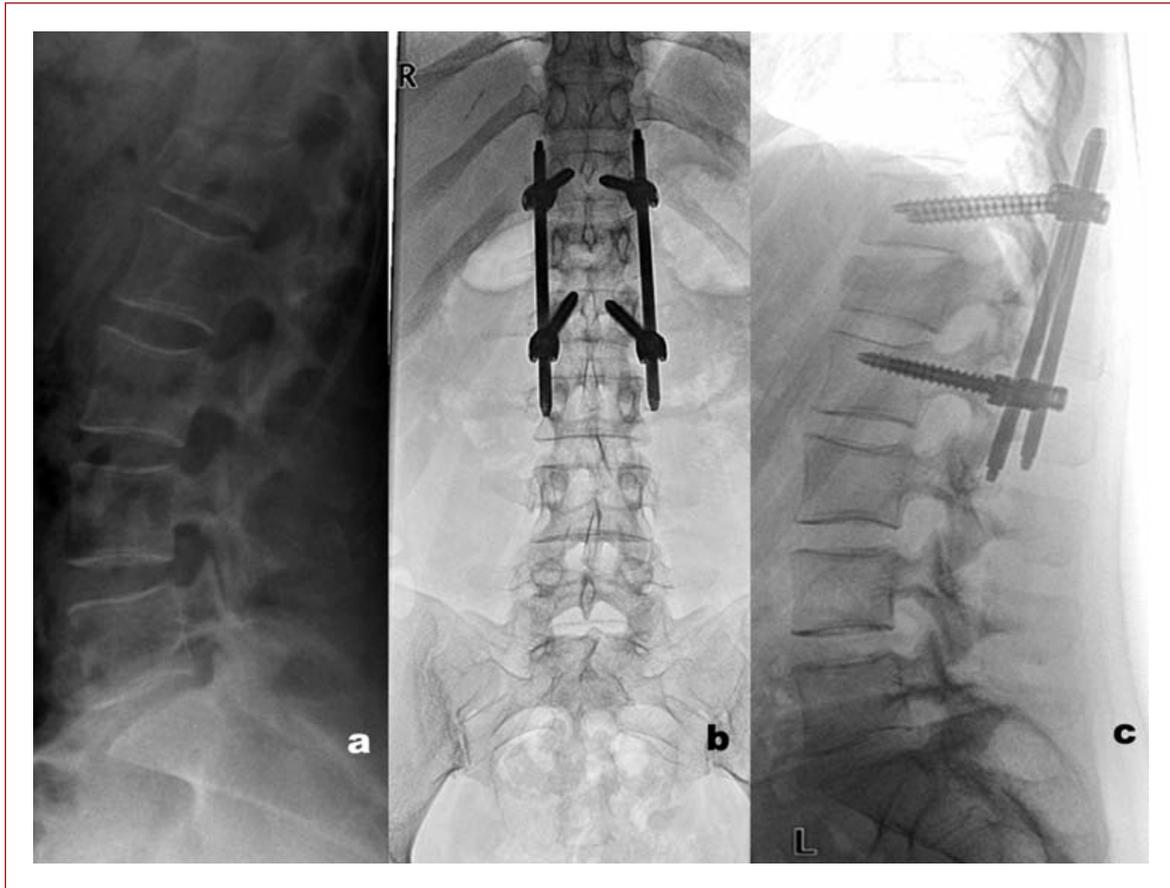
a. Preoperative lateral radiography of a patient with a Magerl Type-A.3 fracture in L1 b. AP radiography after T12–L2 percutaneous short instrumentation, c. Lateral radiography after T12–L2 instrumentation.
